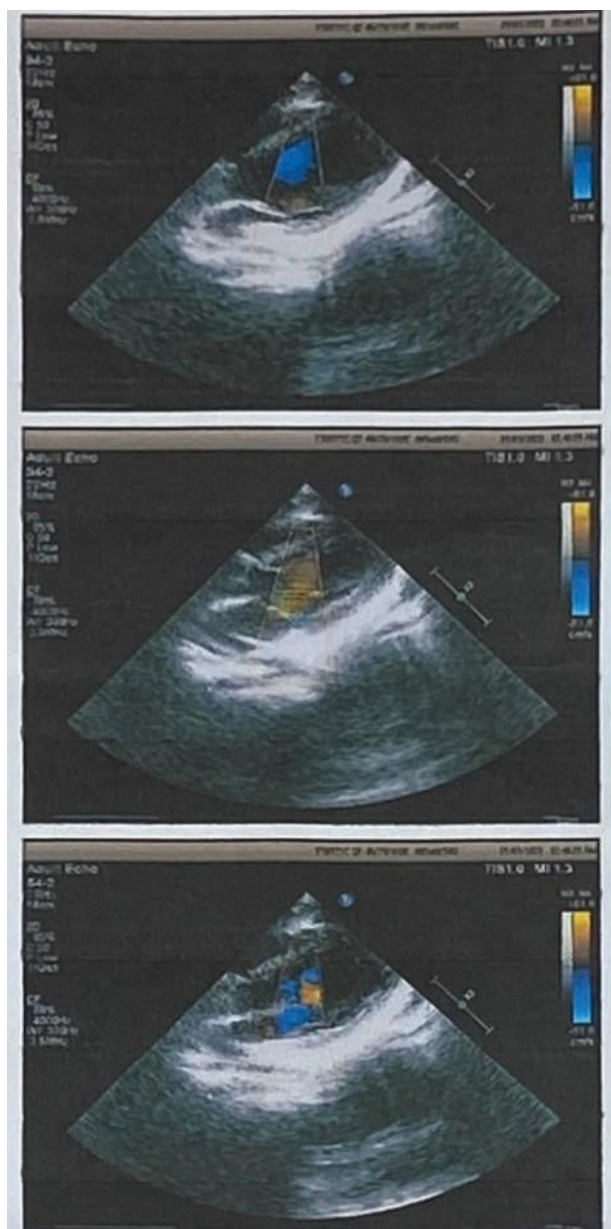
Doppler Echocardiography image revealed nothing abnormal
